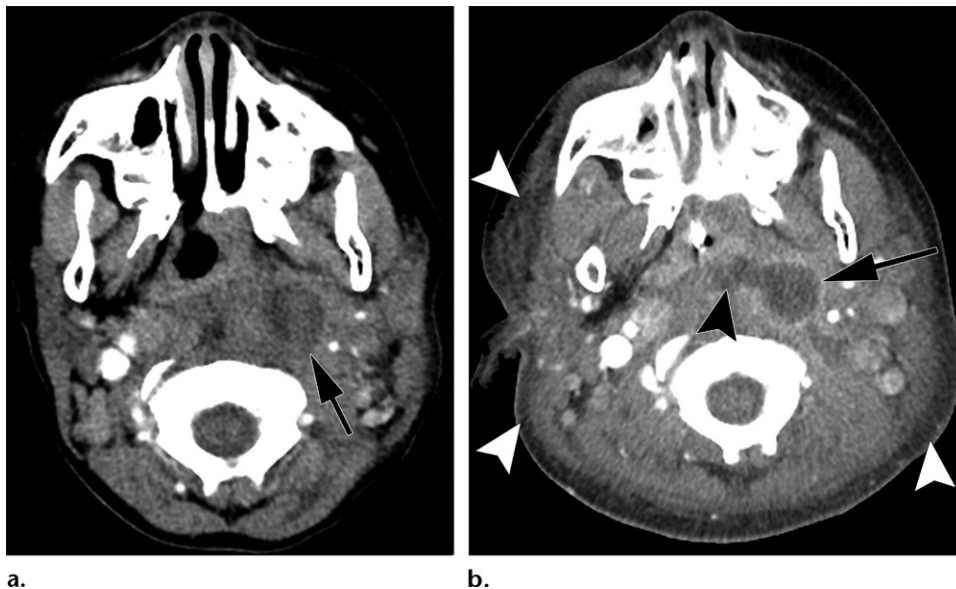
Left retropharyngeal suppurated lymph node and retropharyngeal abscess in a 5-year-old boy. (a) Axial contrast-enhanced CT image shows a left retropharyngeal low-attenuation lymph node (arrow), consistent with internal suppuration. (b) Axial contrast-enhanced CT image obtained 3 days later, by which time the patient's condition had worsened such that intubation was required, shows that the suppurated lymph node (arrow) has ruptured into the retropharyngeal space (black arrowhead). Subcutaneous edema (white arrowheads) also is present.
